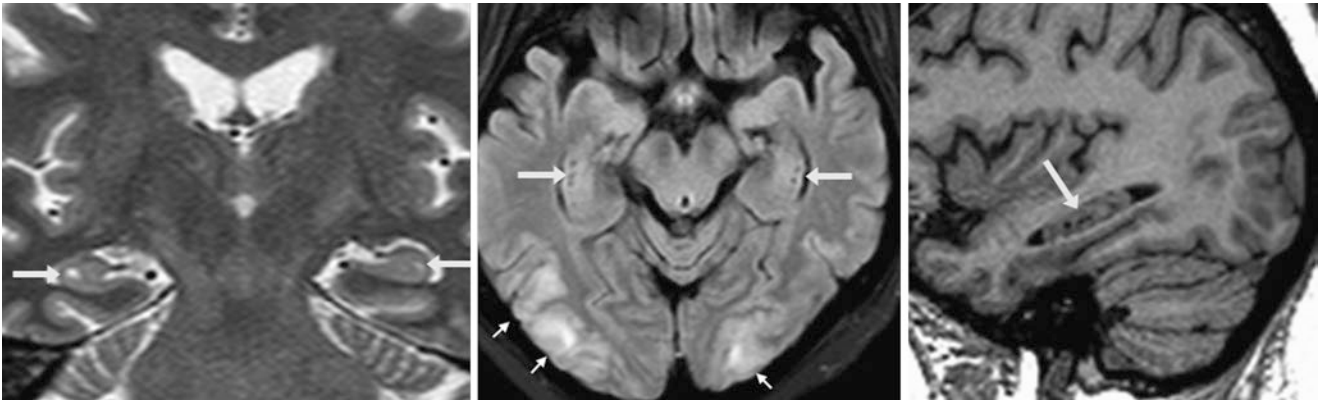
A 52 year old was tested for seizures. Coronal T2WI MRI (*left*) demonstrated tiny, right hippocampal cysts (*arrows*), with a signal akin to that of CSF on FLAIR (*middle*) and sagittal T1WI (*right*). These are visualized on the opposite side to a lesser degree. This hypertensive
